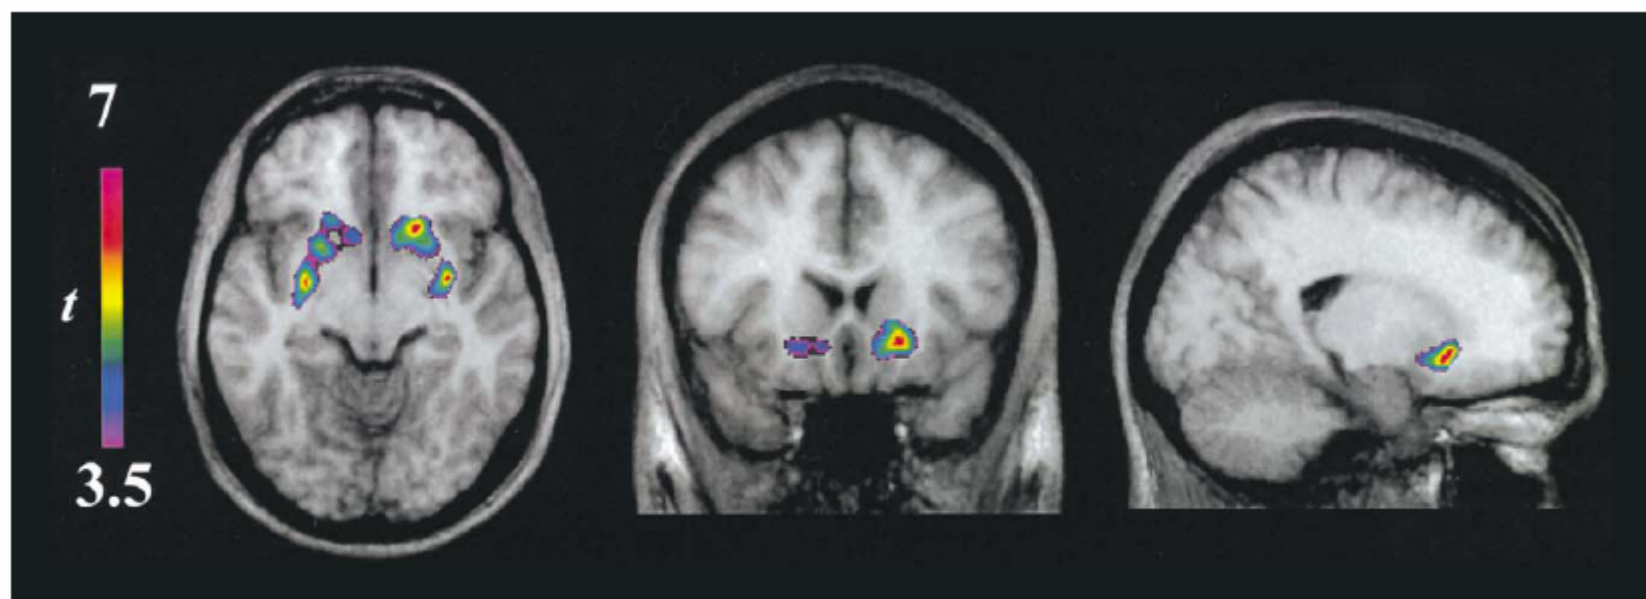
Statistically generated t-map of d-amphetamine-induced changes in [11C]raclopride binding potential superimposed on average MRI. Right side on right.
